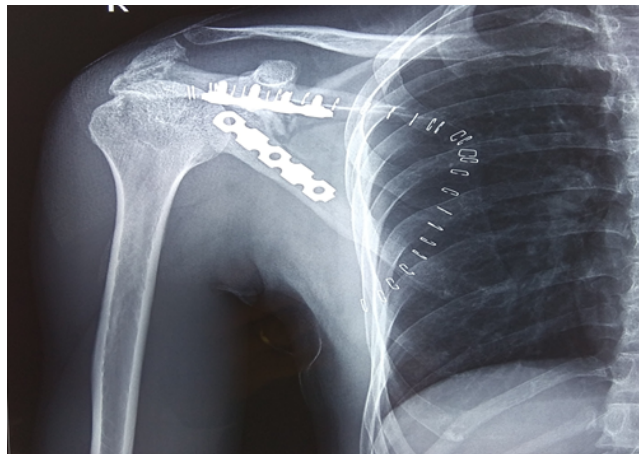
X-ray post-operative
